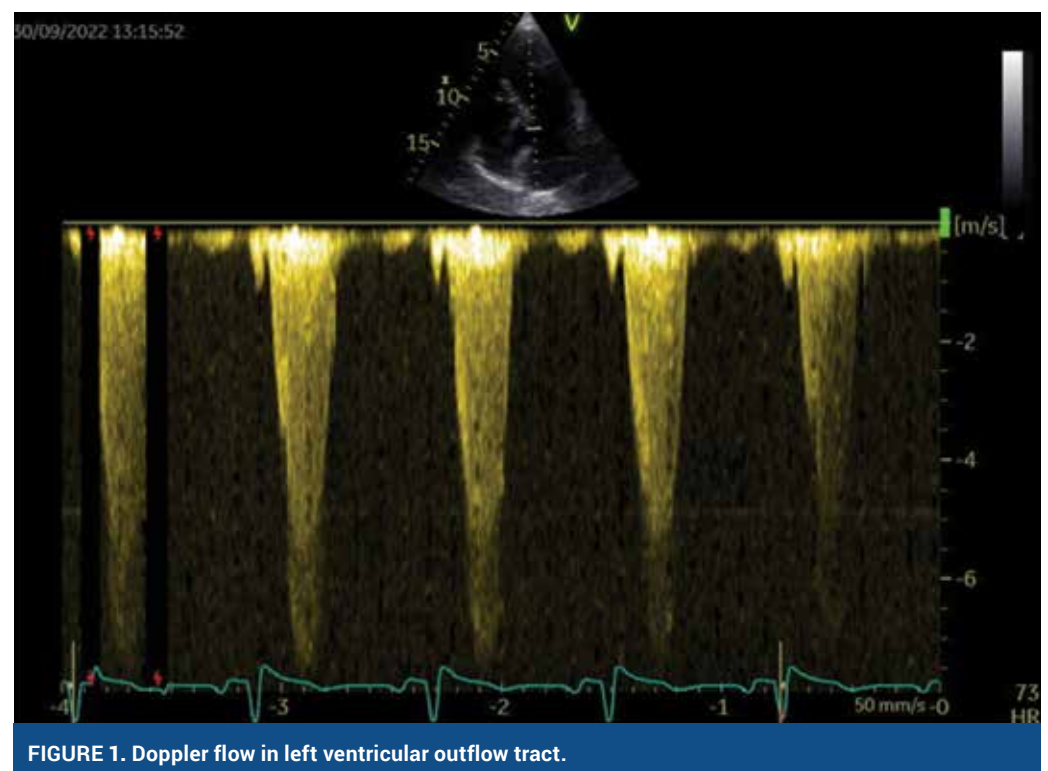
Doppler flow in left ventricular outflow tract.
